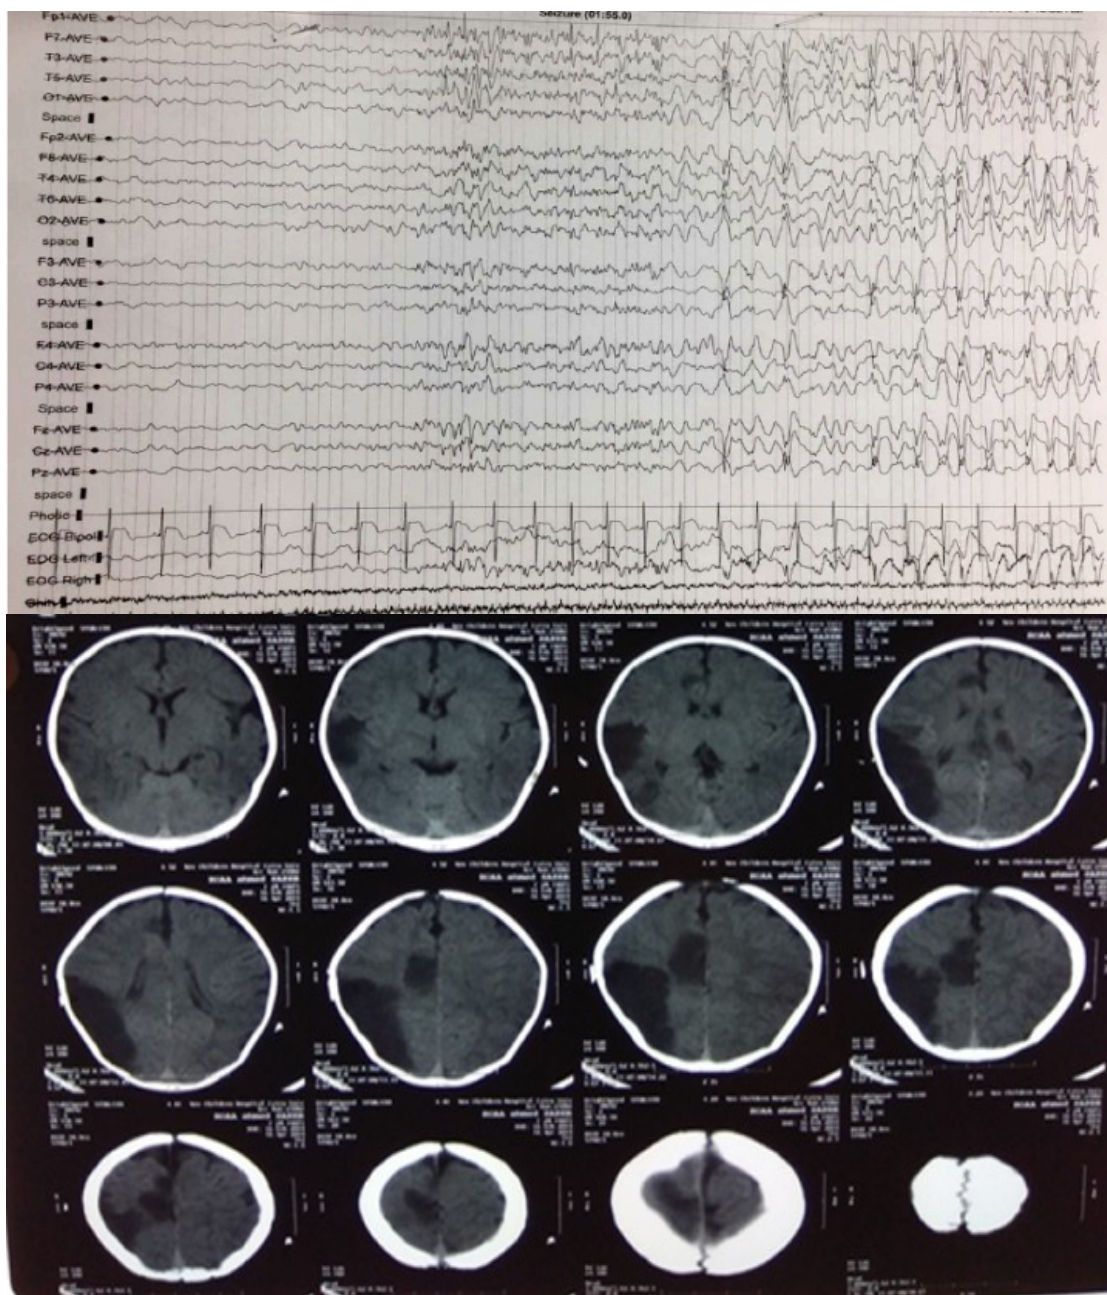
EEG and Non contrast CT brain of a 2 months old girl. EEG showed left frontal epileptogenic focus. CT showed left fronto-parieto-occipital and left basal ganglia ischemic insults.
